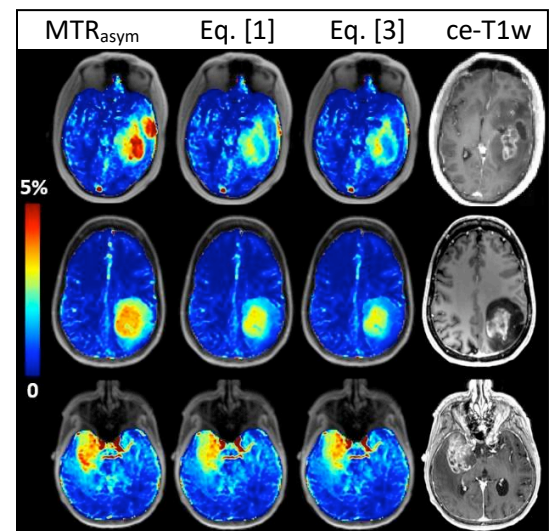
3T snapshot-APT MRI of 3 patients with grade IV tumor. Furthermore, the one in the second row is a IDH mutant with T2 / FLAIR mismatch.
